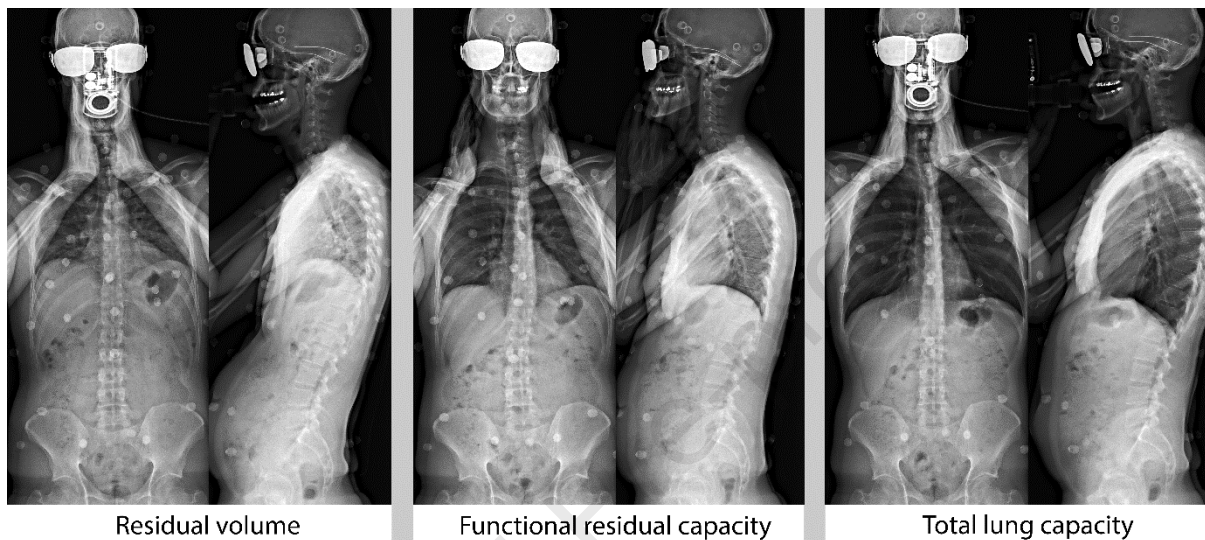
Biplanar x-rays of one 40-year-old healthy male subject at residual volume (minimal volume), functional residual capacity (relaxation volume) and total lung capacity (maximal volume).
